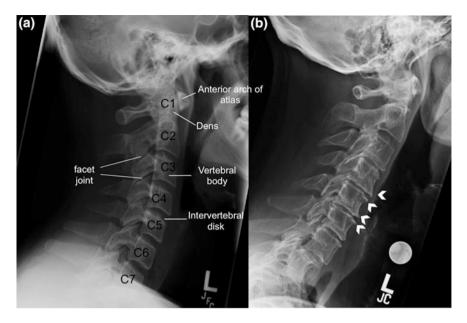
Plain lateral radiographs of a normal cervical spine (a) and of a patient with cervical spondylosis (b). Marginal osteophytes are denoted by arrowheads
